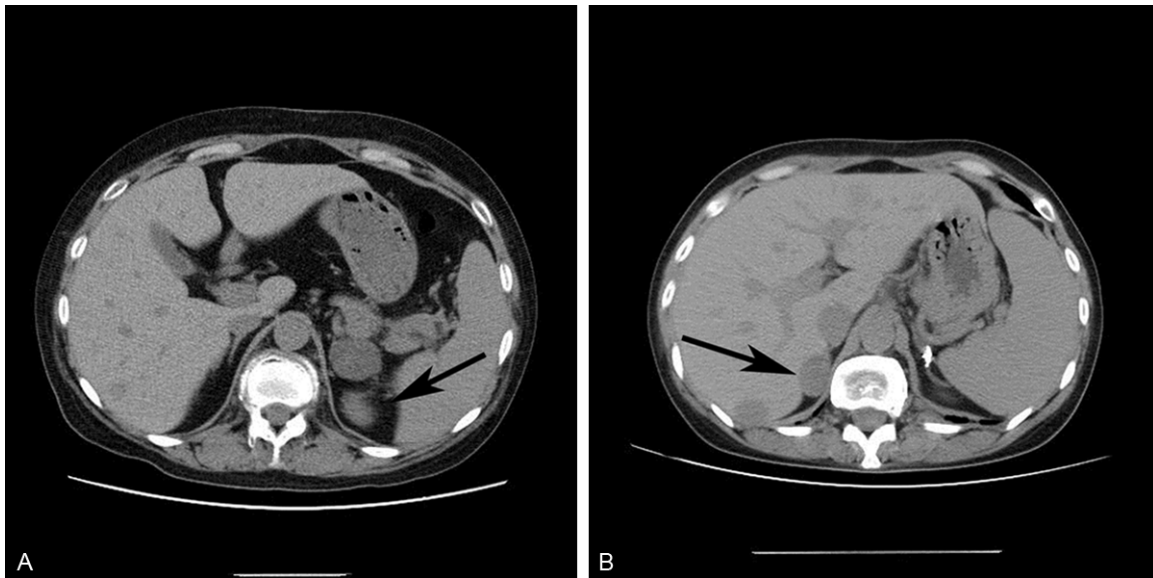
Abdominal CT showing a left adrenal adenoma in 2006 (A) and a right adrenal adenoma in 2013 (B) which are pointed out by black arrows.
